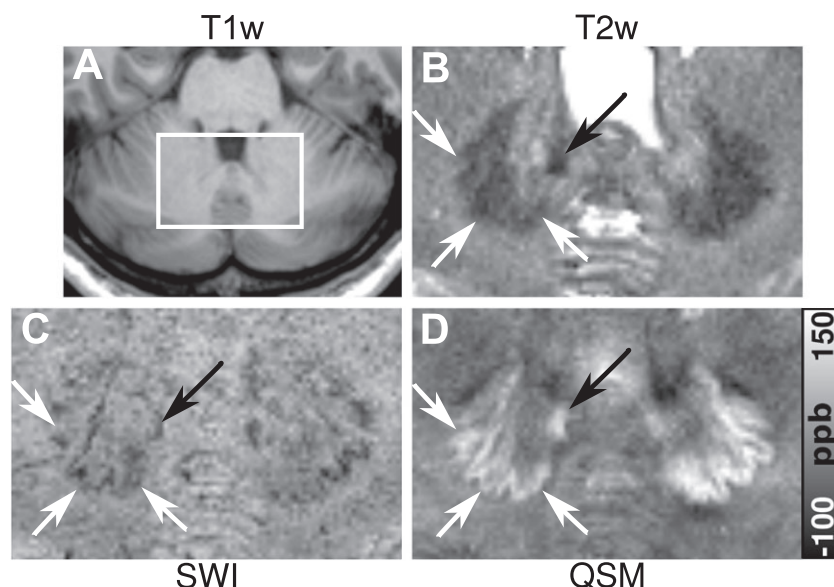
MRI of the cerebellar nuclei at 3 T. (A–D) T_1 -weighted image, T_2 -weighted image, susceptibility-weighted image and susceptibility map. The white box in (A) indicates the region of the enlarged sections in (B–D). The white and black arrows indicate the dentate nucleus and the emboliform nucleus, respectively. [The figure was modified from ref. (166) with permission from Springer.]
